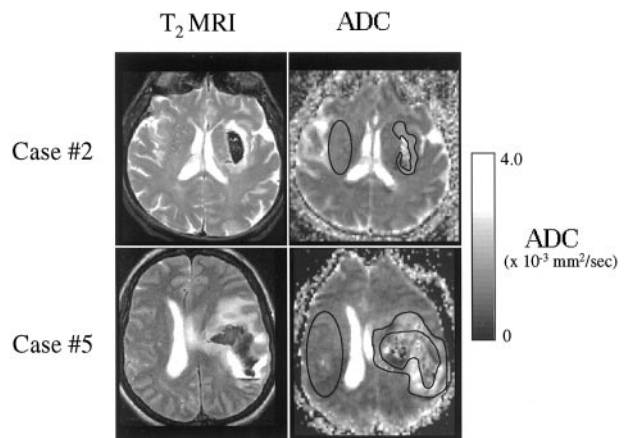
MR images of two patients with ICH show the presence of a hyperintense halo on T2-weighted MR images (*T*₂ MRI) and elevated ADC values in corresponding brain regions on diffusion-weighted images. Both characteristics are compatible with elevated interstitial tissue water content, suggestive of vasogenic brain edema. The diffusion-weighted images show regions of interest in the perihematoma tissue and in the contralateral hemisphere that were chosen for ADC analysis.
